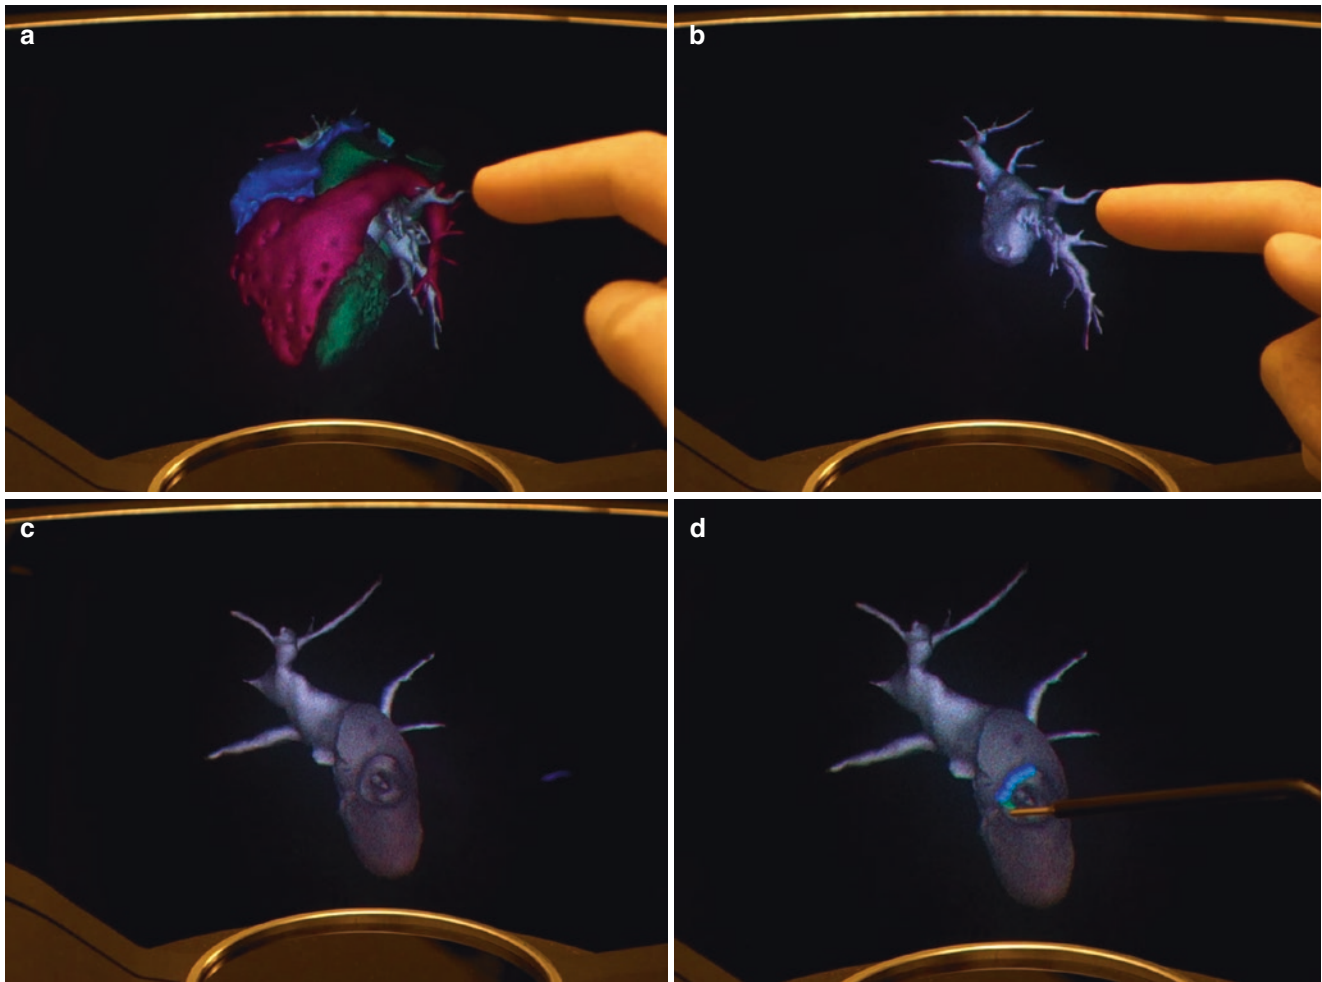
(a) Hologram created from a segmented cardiac CT showing the anterior right ventricle [red] and the posterior left atrium [gray]. The finger is touching the left upper pulmonary vein and rotates the image to the desired viewing angle. (b) The volumetric data of the left atrium is isolated, and the atrium is rotated anteriorly prior to slicing as seen in Fig. 44.3c. (c) The hologram of the left atrial volume has been sliced
